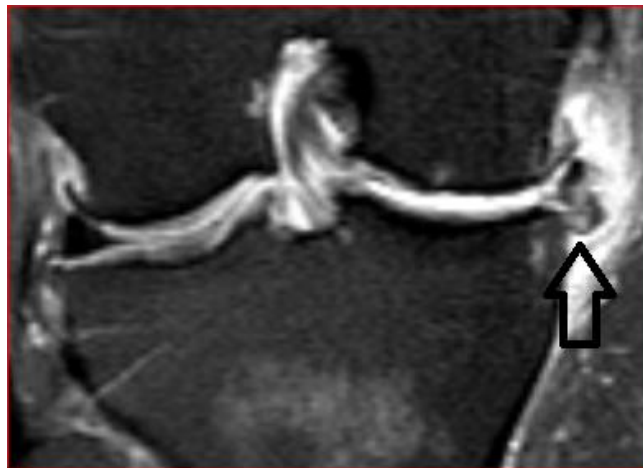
MRI appearance of flipped meniscus. (A.) PD fat sat weighted sagittal image shows fragment of anterior horn which is flipped posteriorly resulting in double up appearance of posterior horn (arrow) and absent anterior horn (arrowhead). (B.) PD fat sat weighted coronal image shows absent part of body of the lateral meniscus. (arrow) (C.) PD fat sat weighted coronal image shows displaced fragment of lateral meniscus in the intercondylar area (arrow).
